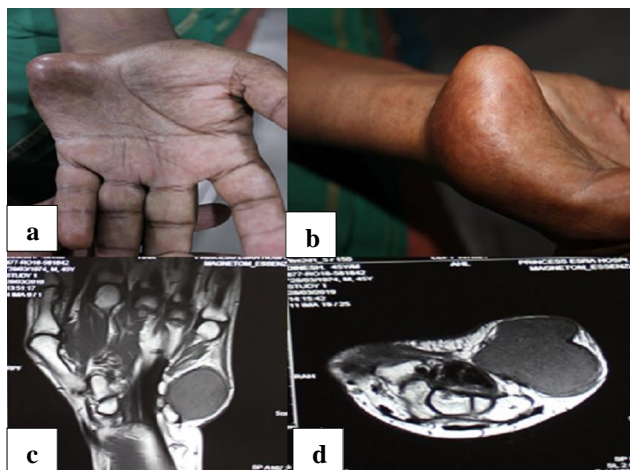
(a) Clinical image showing swelling in the hypothenar area, (b) overlying skin is stretched with no dorsal extension of swelling, (c) MRI shows a hyperintense soft tissue lesion on T2-weighted imaging with flexor tendons displaced, and (d) axial MRI section showing the lesion is hypointense on T1-weighted imaging.
